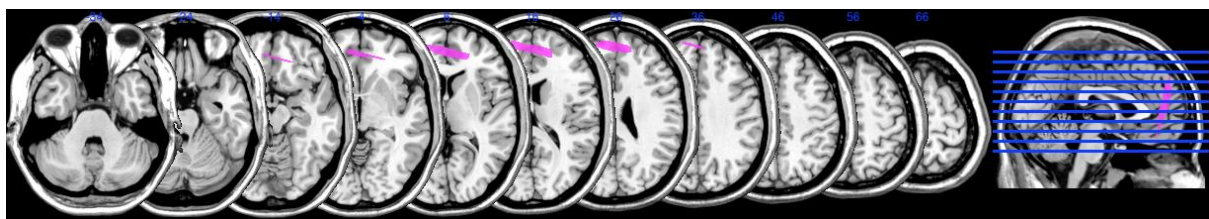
MRI scan of patient NH
